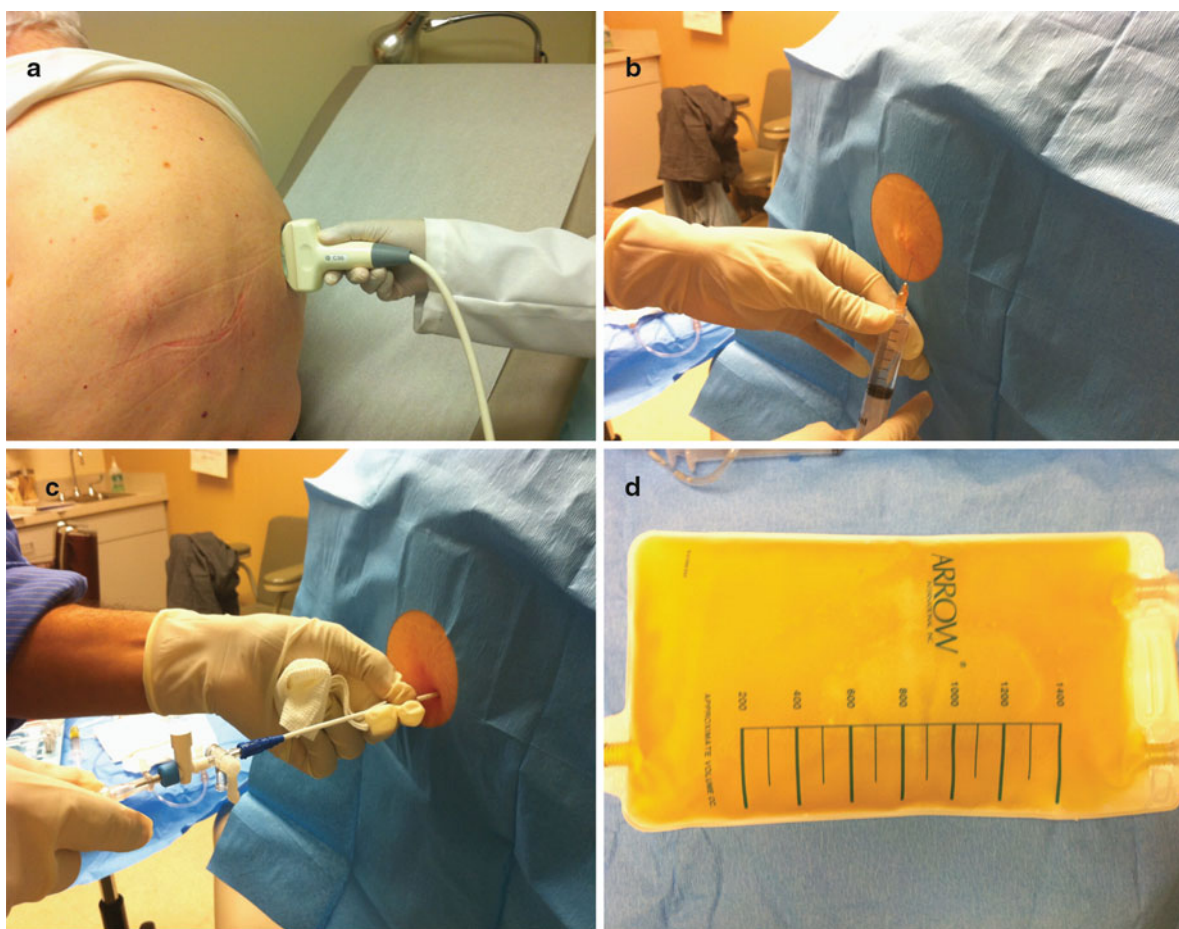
Thoracentesis: (a) Chest ultrasound; (b) Skin anesthetization after sterile skin prep and placement of sterile drape; (c) Placement of thoracentesis needle and catheter; (d) Pleural fluid drained after thoracentesis
